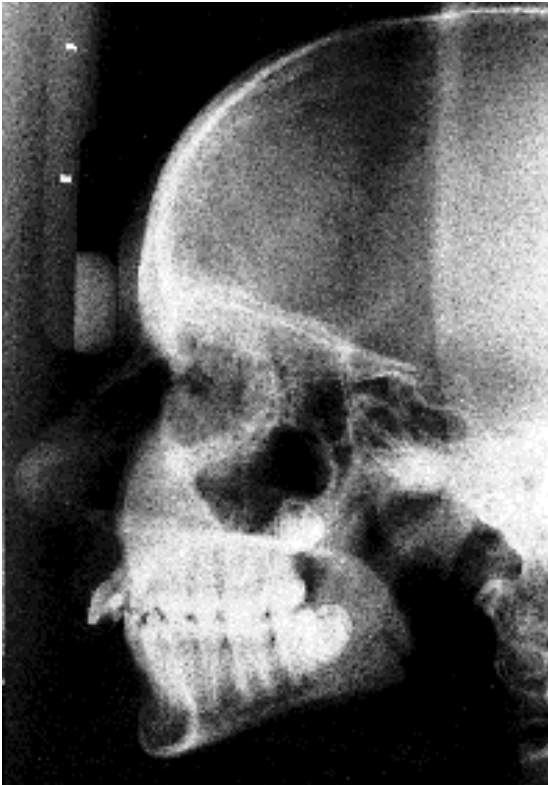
The conventional film radiograph.
